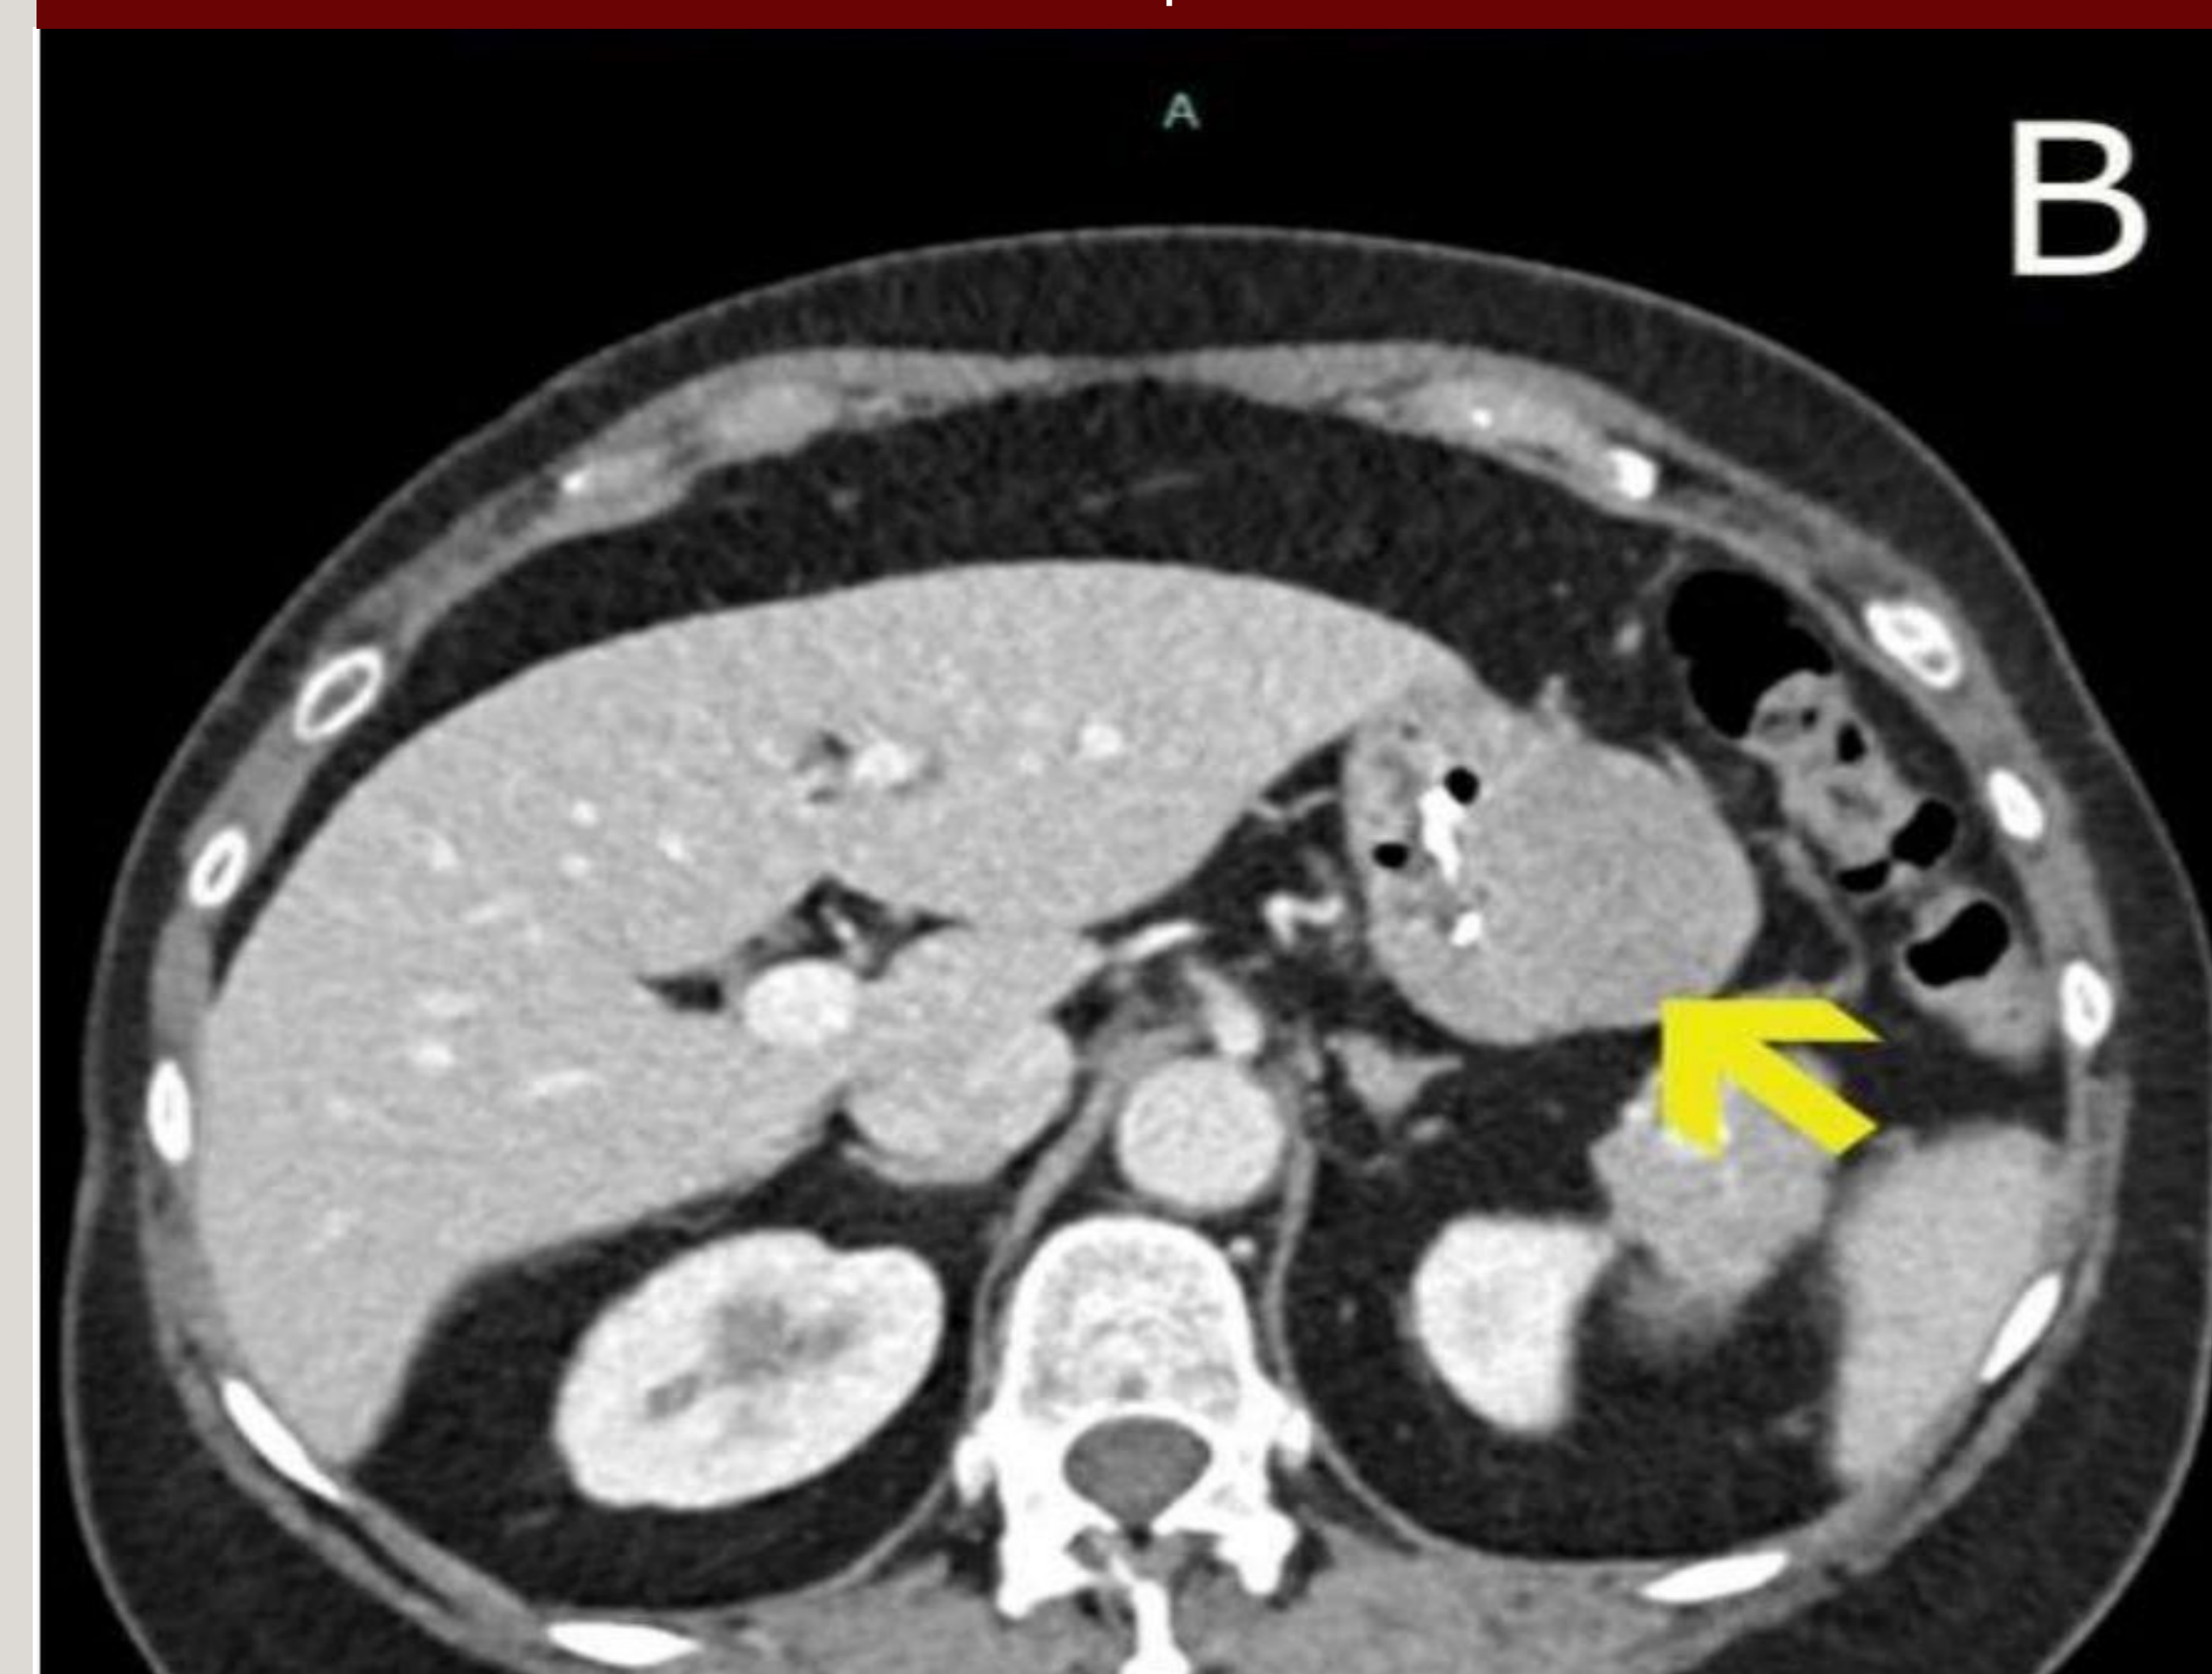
Abdominal CT demonstrated an exophytic mass within the gastric wall with relatively homogenous attenuation and enhancement.
